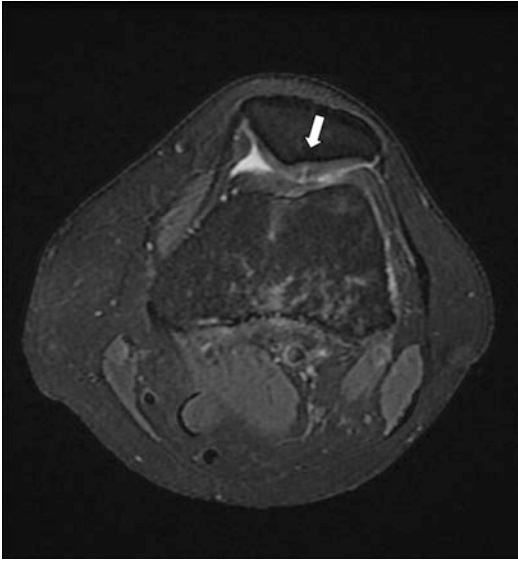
T2 Fat Sat MRI of the knee in axial view, a defect involving more than 50% of patellar cartilage thickness, with no bone edema (grade 3 chondromalacia)
